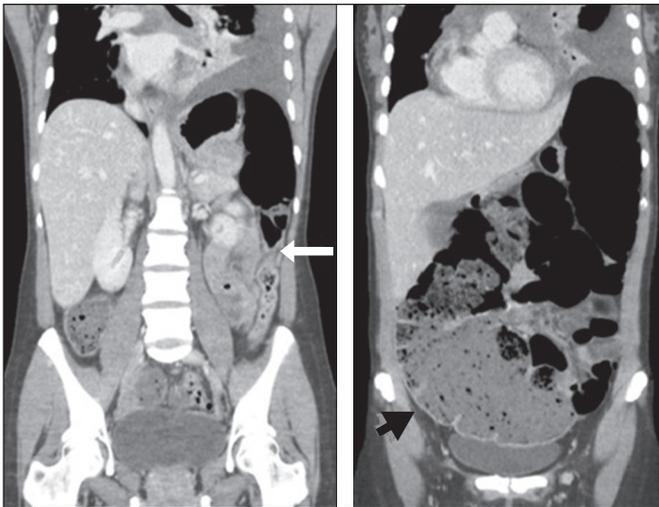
Coronal reconstruction of a CT scan, providing a better view of the transitional zone, where an abrupt transition to a normal caliber segment is observed, with no evident occlusive lesion (arrow). Note the marked dilation of the cecum, which measured 14 cm in diameter (arrowhead). Left pleural effusion can also be seen.
